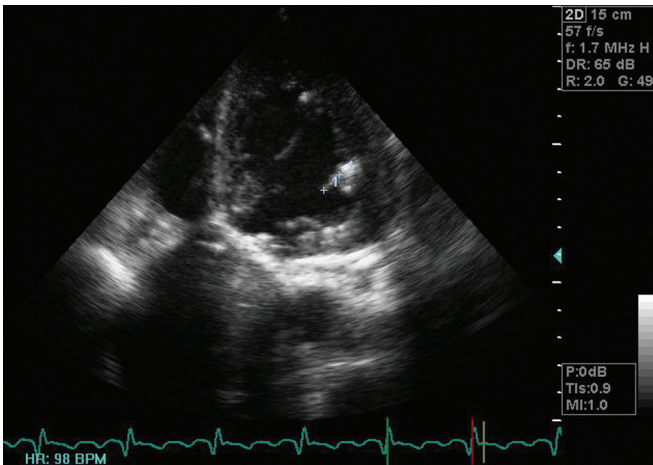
Two-dimensional transthoracic echocardiogram documents decreasing size of the mural vegetation (8 × 5.5 mm) on the left ventricle lateral wall.
